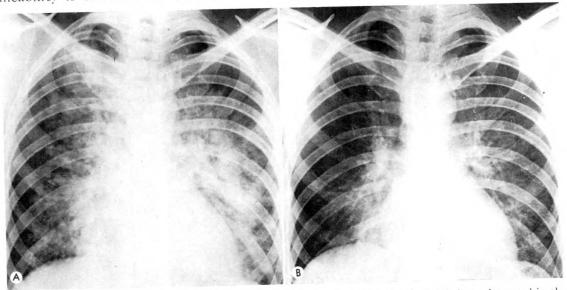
(A and B) Roentgenograms of a young naval aviator who was rescued after being submerged in the ocean. The initial pulmonary edema (A) cleared in 24 hours (B). The edema is due to the excess osmotic pressure of sea water, which pulls fluid from capillaries in the alveolar walls into the interstitial spaces. This layer of fluid presents a barrier to diffusion of O_2 and CO_2 across the alveolar-capillary membrane.
